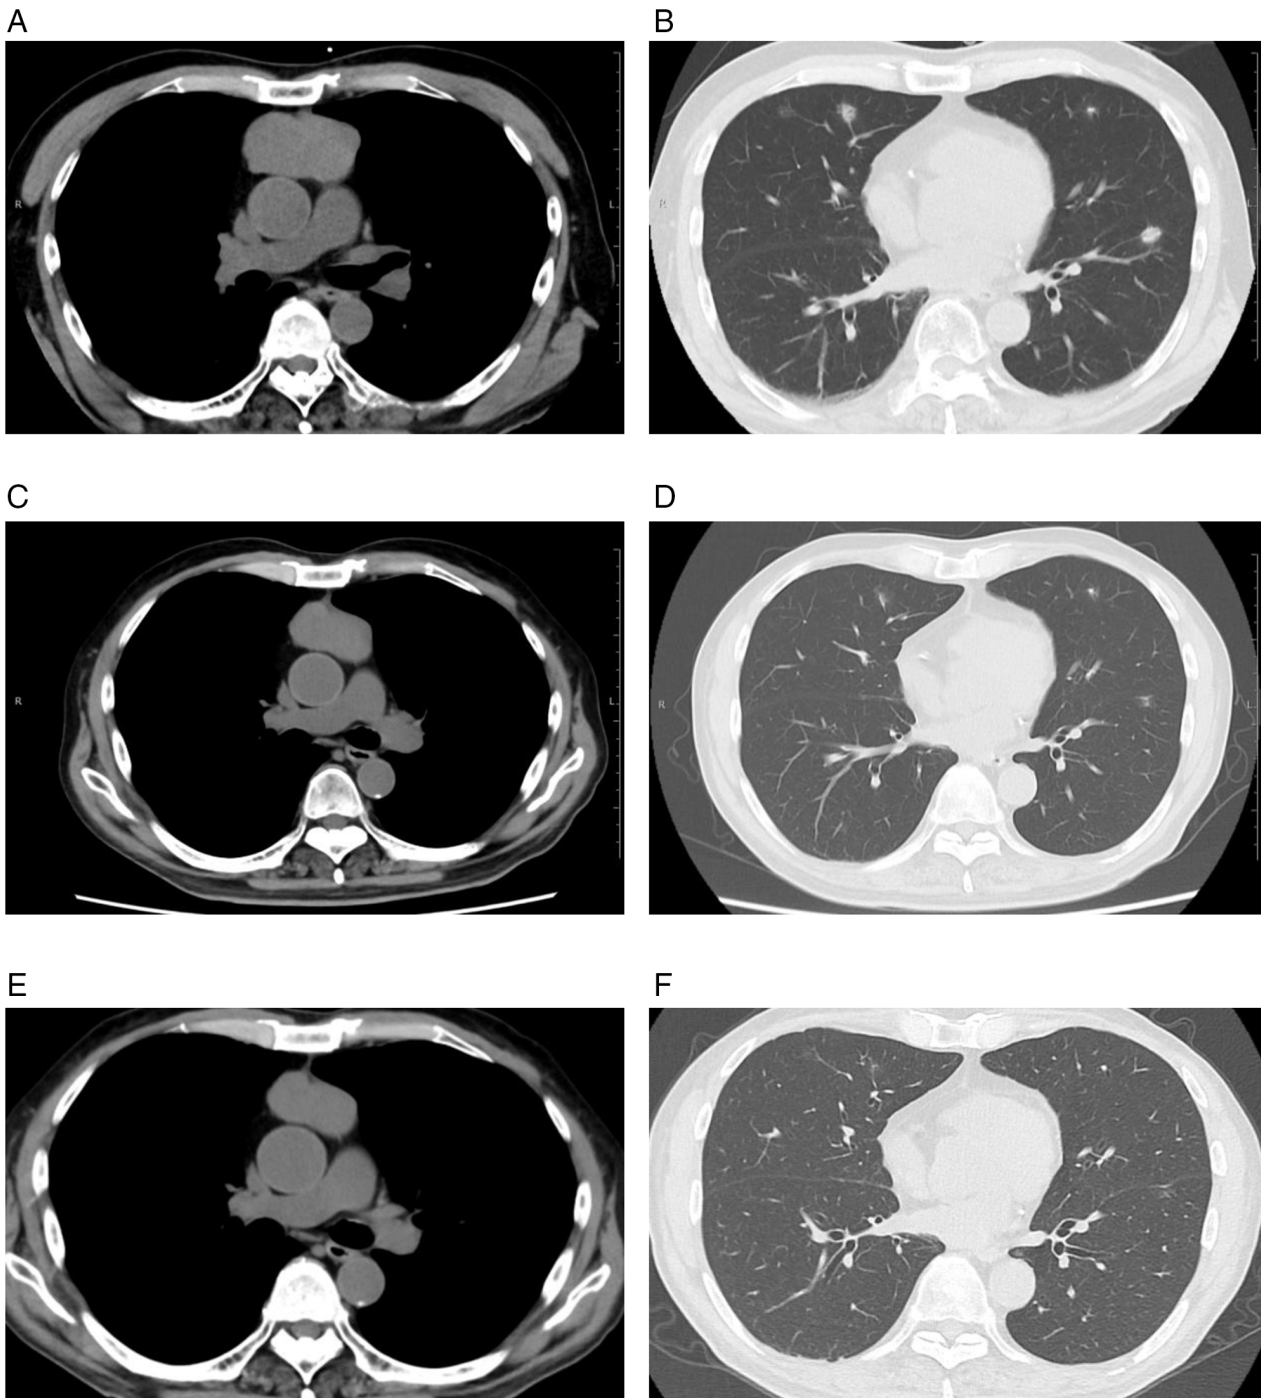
Radiographic findings before and after ADOC chemotherapy. (A) Contrast-enhanced chest CT image obtained in June 2025 prior to chemotherapy demonstrating a 6-cm mass in the anterior mediastinum. (B) Contrast-enhanced chest CT image obtained in June 2025 prior to chemotherapy demonstrating multiple bilateral pulmonary nodules consistent with pulmonary metastases. (C) Contrast-enhanced chest CT image obtained in September 2025 after 4 cycles of ADOC chemotherapy demonstrating shrinkage of the anterior mediastinal mass. (D) Contrast-enhanced chest CT image obtained in September 2025 after 4 cycles of ADOC chemotherapy demonstrating shrinkage of the multiple bilateral pulmonary nodules, some of which became less conspicuous. (E) Contrast-enhanced chest CT image obtained in November 2025 after 6 cycles of ADOC chemotherapy demonstrating further reduction of the anterior mediastinal mass. (F) Contrast-enhanced chest CT image obtained in November 2025 after 6 cycles of ADOC chemotherapy demonstrating sustained shrinkage of the bilateral pulmonary nodules. ADOC, doxorubicin, cisplatin, vincristine and cyclophosphamide; CT, computed tomography.
